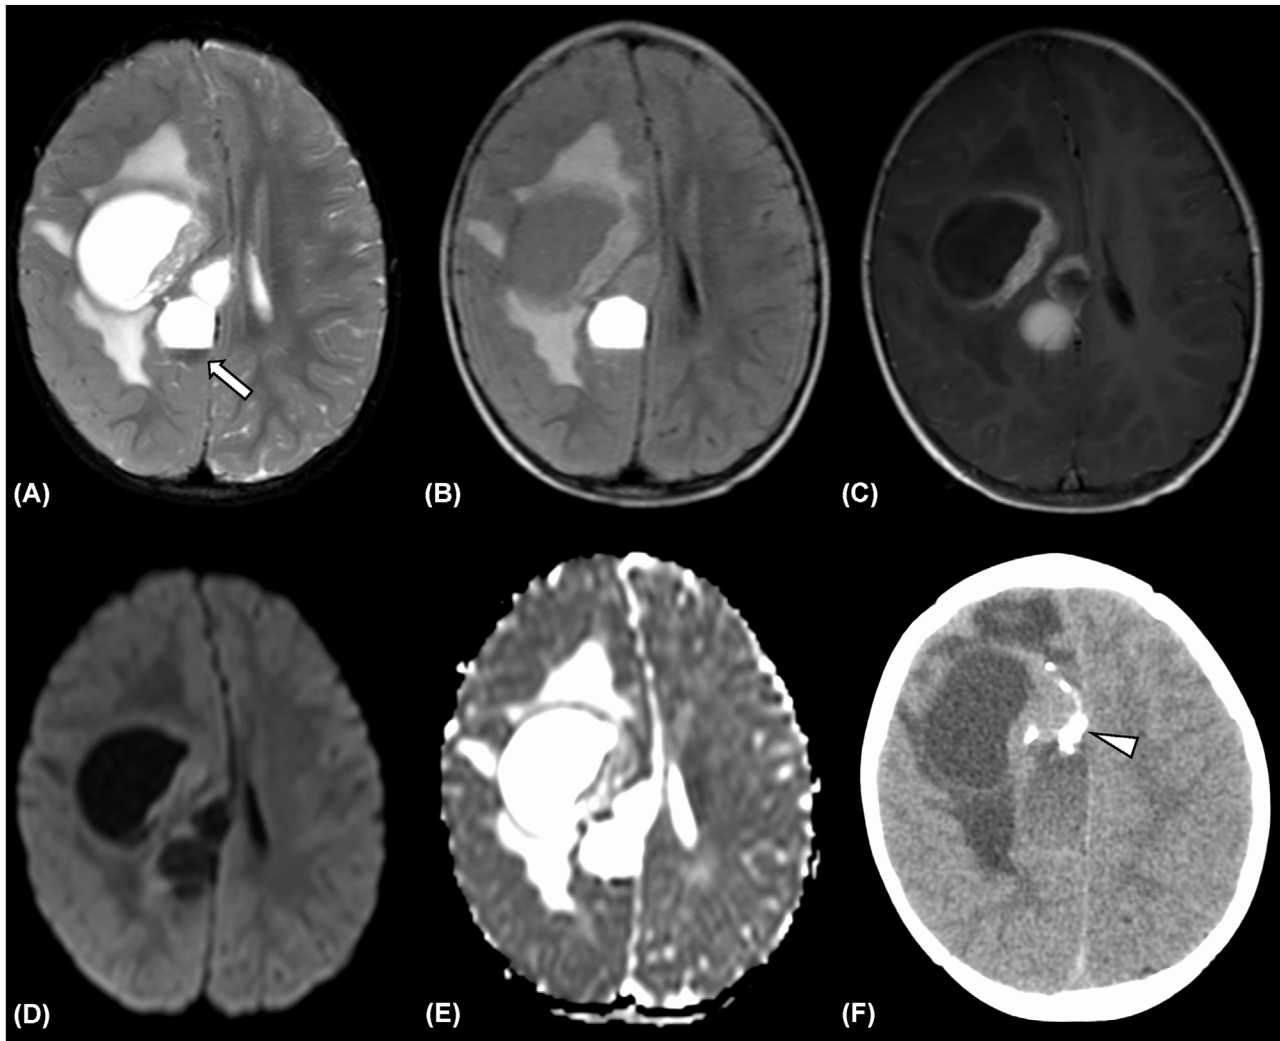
Supratentorial high-grade astroblastoma in a 1-year-old child presenting with weakness of the left upper and lower extremities (patient 1). The solid components of the tumor show high intensity on fat-suppressed T2-weighted image (A) and fluid-attenuated inversion recovery images (B) and low intensity on T1-weighted image (not shown) with heterogeneous enhancement (C). Diffusion restriction is observed with the mean apparent diffusion coefficient value of $0.81 \times 10^{-3} \text{ mm}^2/\text{s}$ (D, E). The cystic components show various signal intensities on each sequence with a fluid-fluid level indicating intratumoral hemorrhage (A: arrows). Unenhanced CT shows an intratumoral calcification (F: arrowhead). The tumor appears as a solid mass with surrounding cysts (morphology I)
